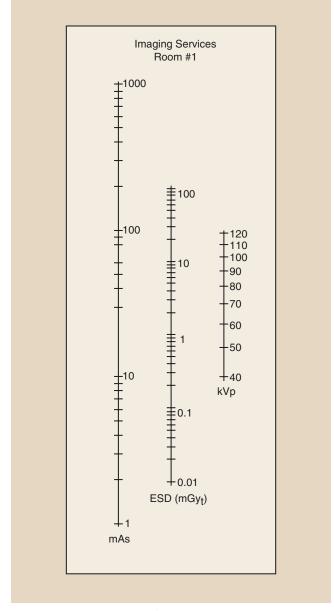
This type of nomogram is very accurate but must be fashioned individually for each radiographic unit. (Courtesy Michael D. Harpen, University of South Alabama.)
